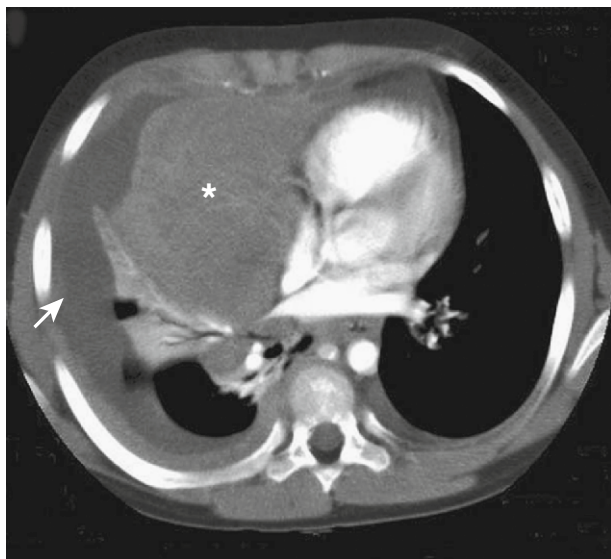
This 8-year-old presented with dyspnea. The CT scan shows a very large anterolateral mediastinal mass (asterisk). There is also collapse of the adjacent right lung and a rather large pleural effusion (arrow). The diagnosis of T cell lymphoma was made on thoracentesis.
